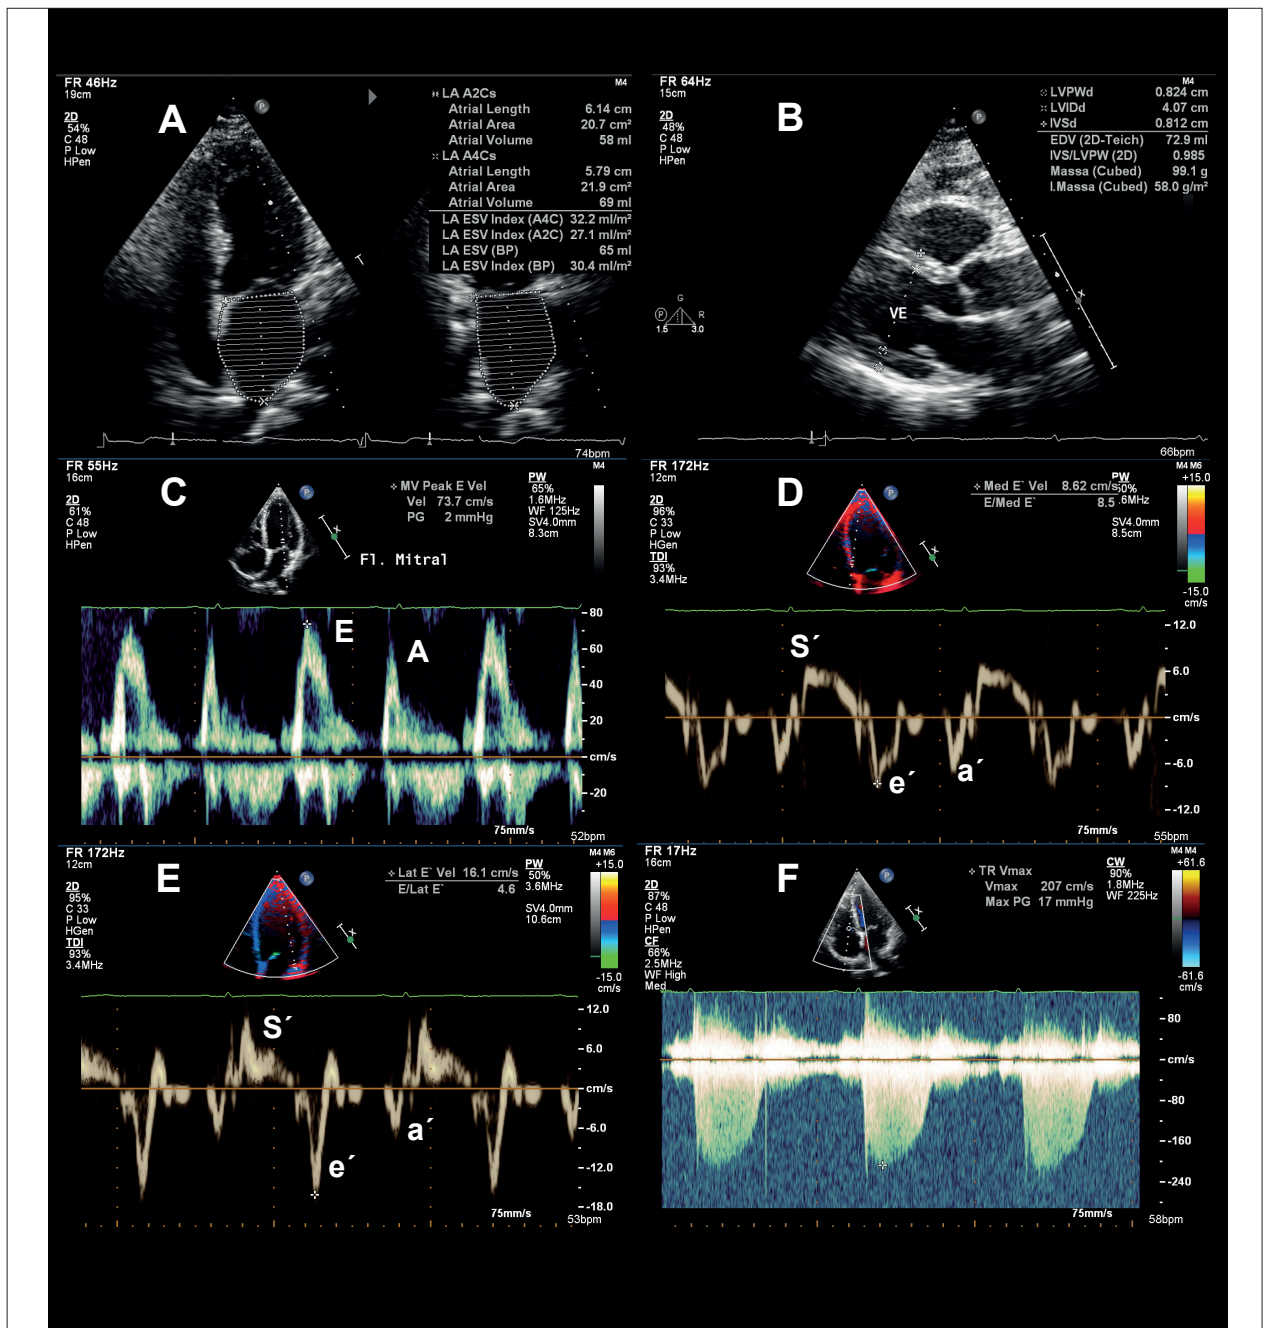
Morphological (A and B) and functional (C to F) echocardiographic criteria for the diagnostic algorithm application in patients with suspected HFpEF. The morphological criteria included the measurement of the left atrial volume index (A) and the calculation of the myocardial mass index and relative wall thickness (B). The functional criteria include the E/e' ratio calculated from the measurement of the E wave on mitral Doppler (C) ($v = 73.7$ cm/s) and e' wave septal (D) ($v = 8.6$ cm/s) and lateral (E) ($v = 16.1$ cm/s) velocities on tissue Doppler, in addition to the tricuspid regurgitation jet peak velocity ($v = 2.07$ cm/s) to measure the pulmonary artery systolic pressure (F). *v*: velocity.
